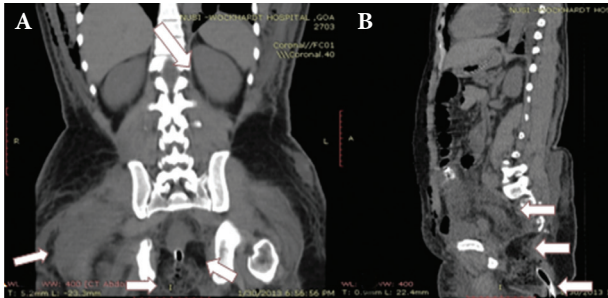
Plain CT scan abdomen (A) coronal section demonstrating intact levator ani, avulsed anorectal stump, ischioanal fossae with traumatic cavity (medial arrows) and abscess cavity right thigh (lateral arrow) (B) sagittal section demonstrating avulsed anorectal stump separated from lower sacrum and coccyx (top arrow) with cavity below (middle arrow) with tube exiting at skin level (lower arrow)
